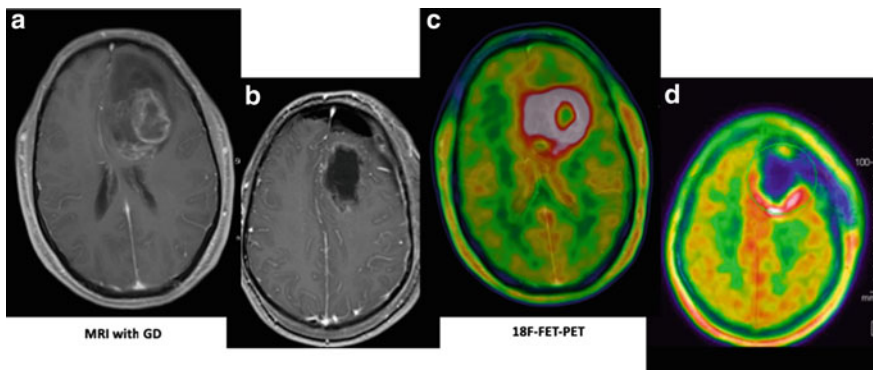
a MRI T1+Gd before and after surgery (a and b) with corresponding F18-FET-PET imaging pre- and postoperatively (c and d). The enhanced metabolism of the tumor can be visualized using PET imaging. Images are reprinted with permission of the Department of Nuclear Medicine, University Hospital Münster, Germany
